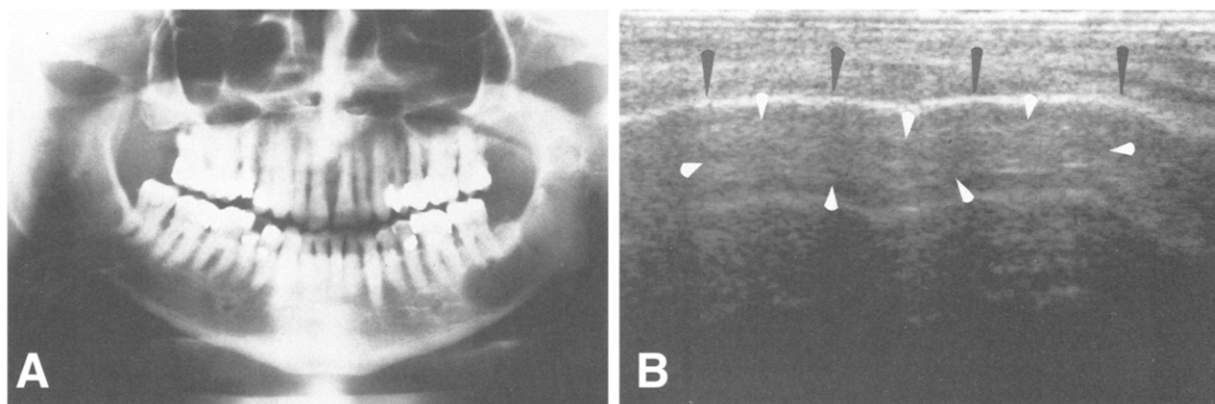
A, Panoramic radiograph of keratocyst of left body, angle, and ramus of mandible in 25-year-old white man. Lesion shows well-defined multilocular radiolucent image causing root resorption on first and second molars. B, US image of same lesion shows exclusive hypoechoic aspect of keratocyst (*white arrows*) because of presence of dense and thick content (keratin). The integrity of buccal cortical surface of the mandible (*black arrows*) is also demonstrated and makes visualization of US image more difficult.
